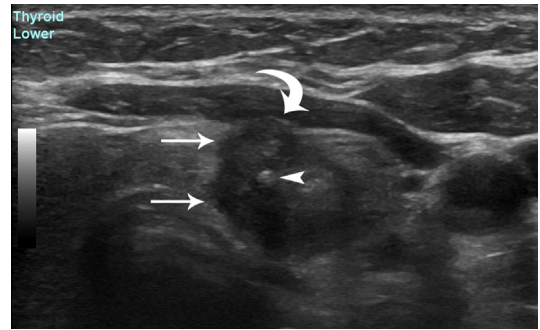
A 58-year-old woman with well-differentiated papillary thyroid cancer. Transverse gray-scale ultrasound image shows a hypoechoic solid nodule with irregular margins (*arrows*), extension to the thyroid capsular surface (*curved arrow*), and central calcification (*arrowhead*). On pathology evaluation, the tumor focally extended beyond the thyroid border.
